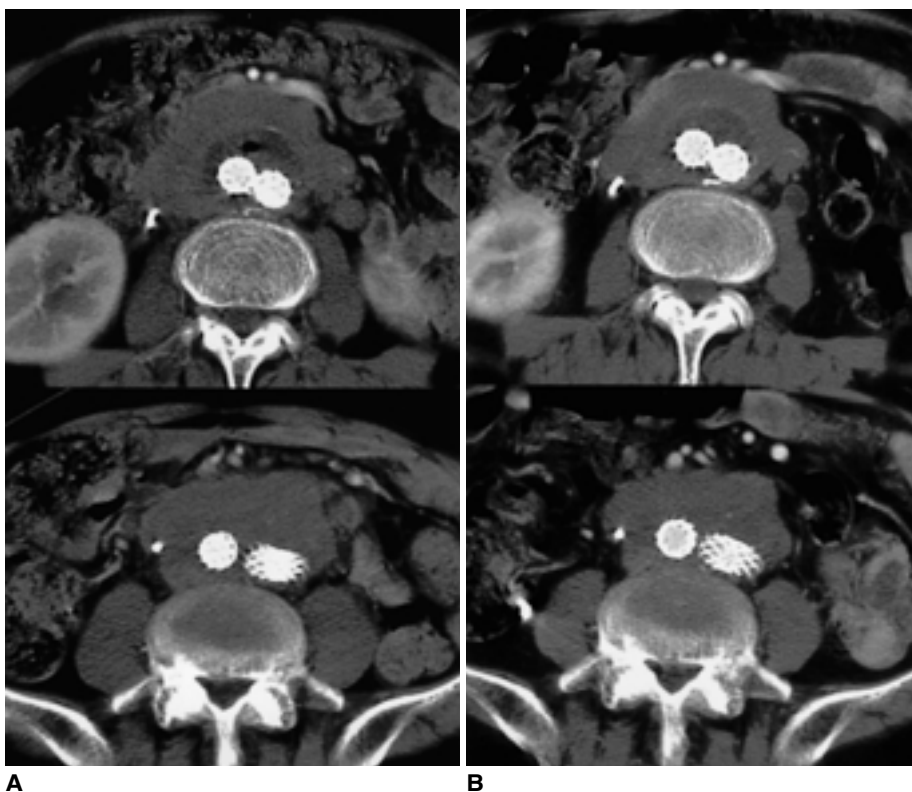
A. One-month follow-up CT scan shows that the abdominal aortic aneurysm is completely excluded by stent-graft. Note that the size of the surrounding soft tissue mass has not changed. B. Six-month follow-up CT scan shows that the size of the surrounding soft tissue mass encasing aorta has slightly decreased, probably due to steroid administration.
